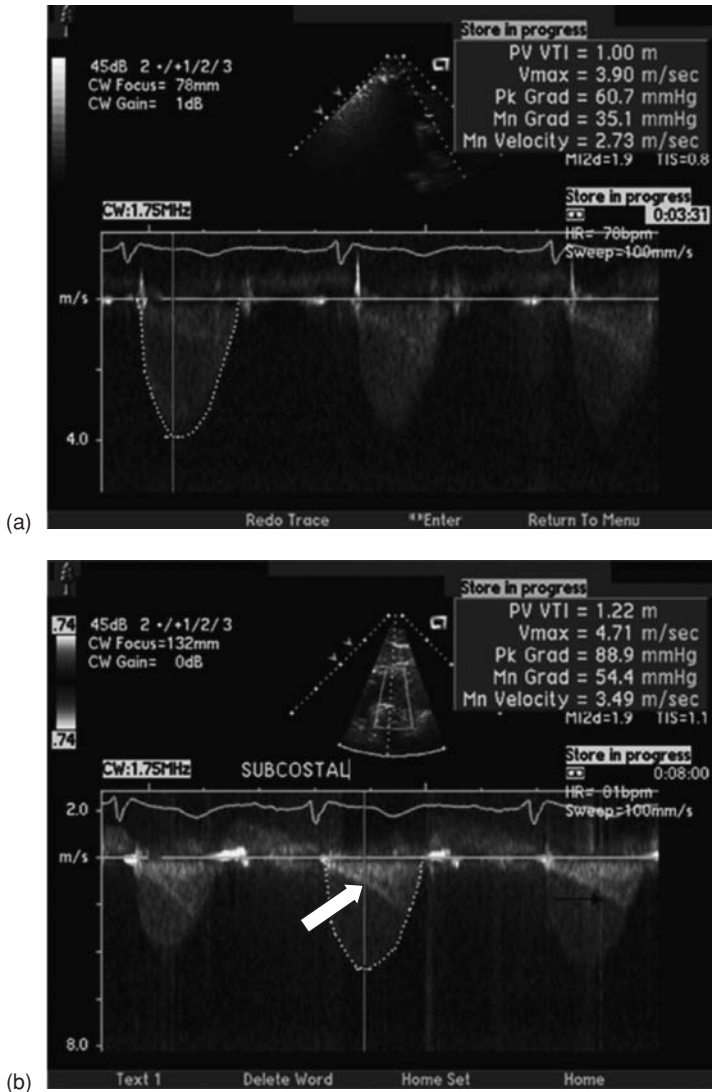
(a) Continuous wave Doppler in the parasternal short axis view reveals a peak gradient across pulmonary valve of 61 mm Hg. (b) Imaging in subcostal plane reveal significantly higher Doppler gradient, measuring 89 mm Hg. Note superimposed late peaking gradient which measures 25 mm Hg (arrow), representing dynamic outflow obstruction due to infundibular hypertrophy. (Courtesy of Dr. George Cohen.)
